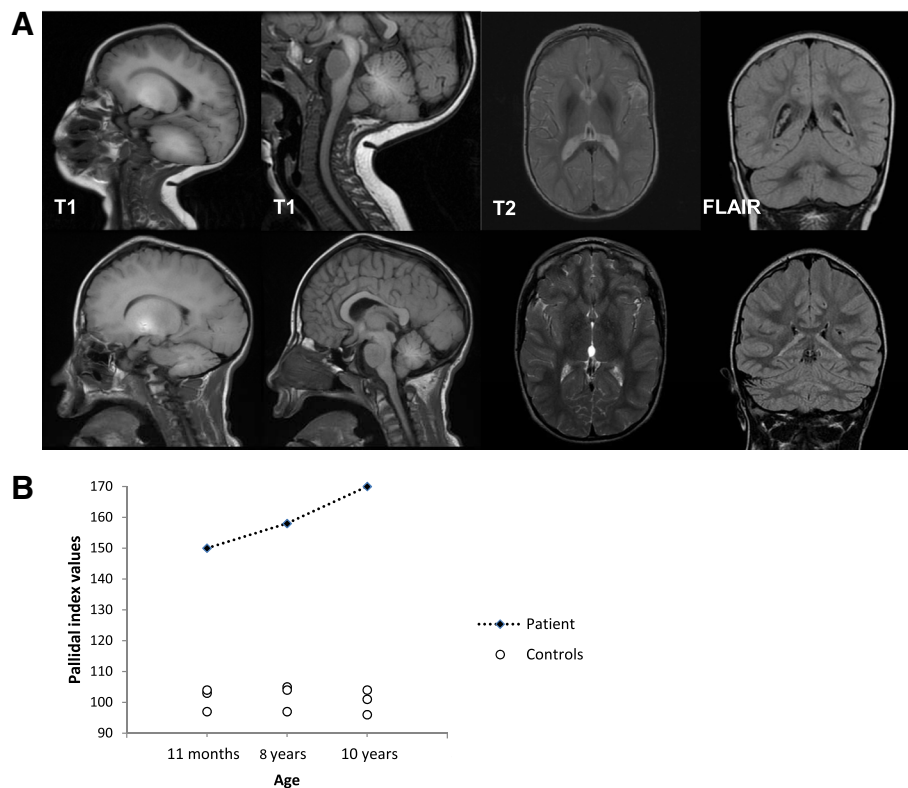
Radiological findings from the patient. a: Brain MRI of the patient at 11 months (first line) shows a high-T1 and low T2 signal in the pallidi and dentate nuclei. MRI at 10 years (second line) shows persistent T1-hyperintensity of the globi pallidi, volume loss, gliosis and atrophy of the dentate nuclei and moderate atrophy of cerebellar folia. b: Distribution of individual PI scores in patient and controls
